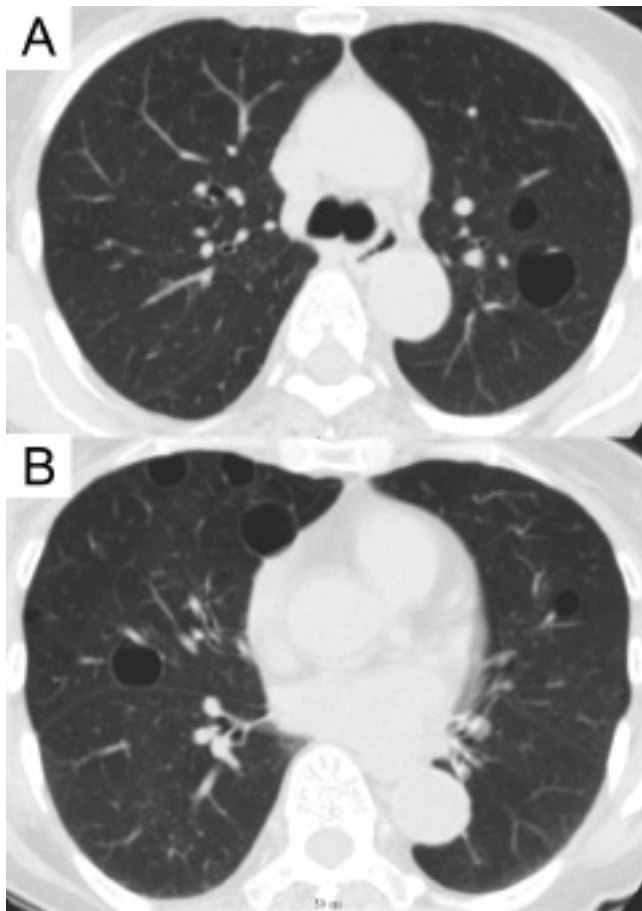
A 73-year-old woman with primary Sjögren's syndrome without anti-SSB/La, accompanied by mixed-type cryoglobulinemia, and mucosa-associated lymphoid tissue lymphoma in salivary glands. Thin-section CT scans at the level of carina (A) and at the level where the right inferior lobar bronchus divides into basal bronchi (B) show multiple solitary thin-walled lung cysts without surrounding abnormal findings.
